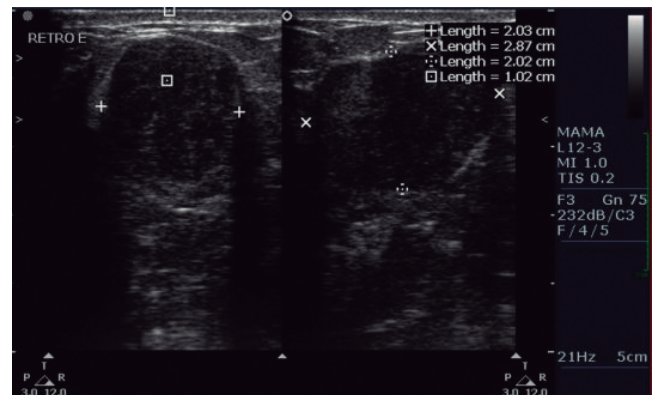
Ultrasonography of the left breast showing a solid hypoechoic nodule measuring $2.9 \times 2.0 \times 2.0$ cm, and 1.0 cm distant from the skin.
